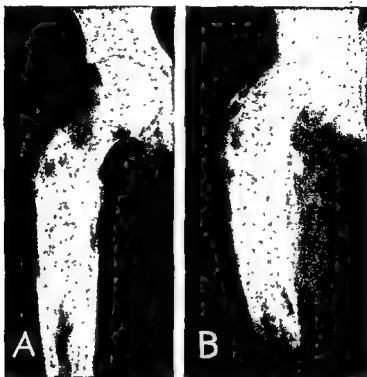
Endothelioma of femur. The appearance in A was strongly suggestive of infection rather than tumor. Following a mild exposure to roentgen therapy a biopsy revealed no evidence of tumor. This was construed as favoring the diagnosis of bone infection and it was not until twelve months later that the appearance seen in B aroused grave suspicion, prompting another biopsy which established the diagnosis of endothelioma.
